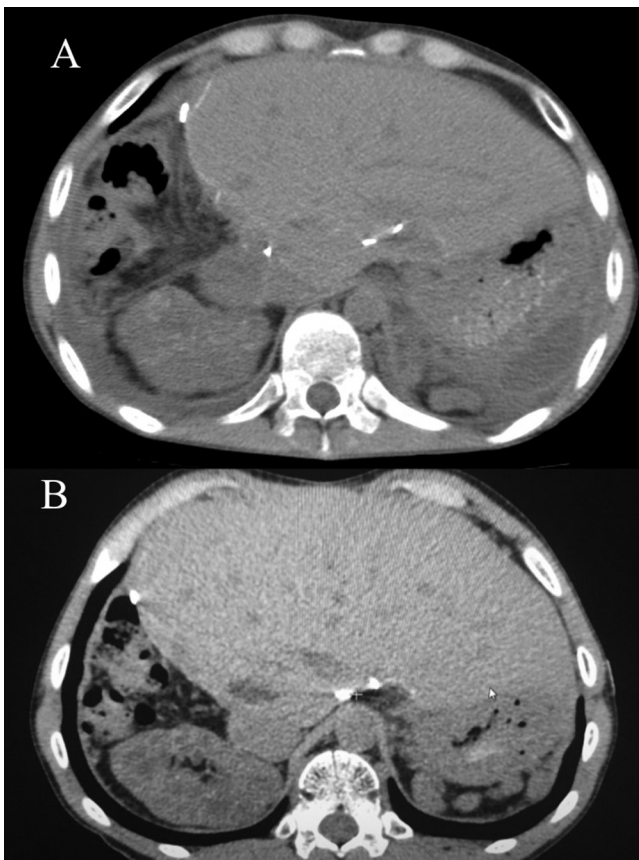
Post-operative CT findings in the recipient. The CT findings at 132 days (A) and at 19 months (B) were shown.
